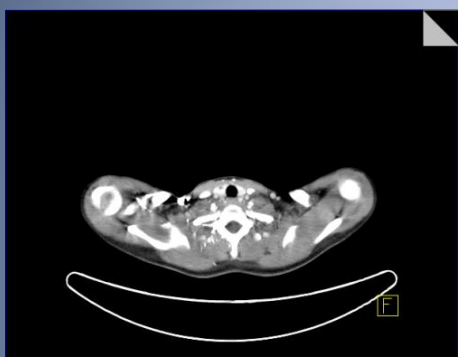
Abbreviations: FDG, fluorodeoxyglucose; PET, positron emission tomography; BM, bone marrow; HL, Hodgkin's lymphoma.
